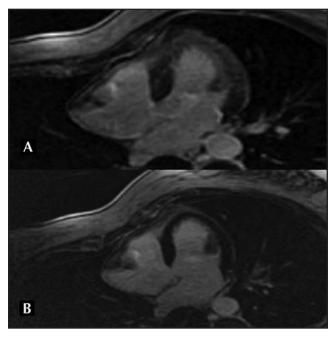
A, MRI showing mild gadolinium late enhancement in the area of acute wall motion abnormality in takotsubo-like syndrome 24 hours after admission. B, Same patient 30 days later without any gadolinium late enhancement.
